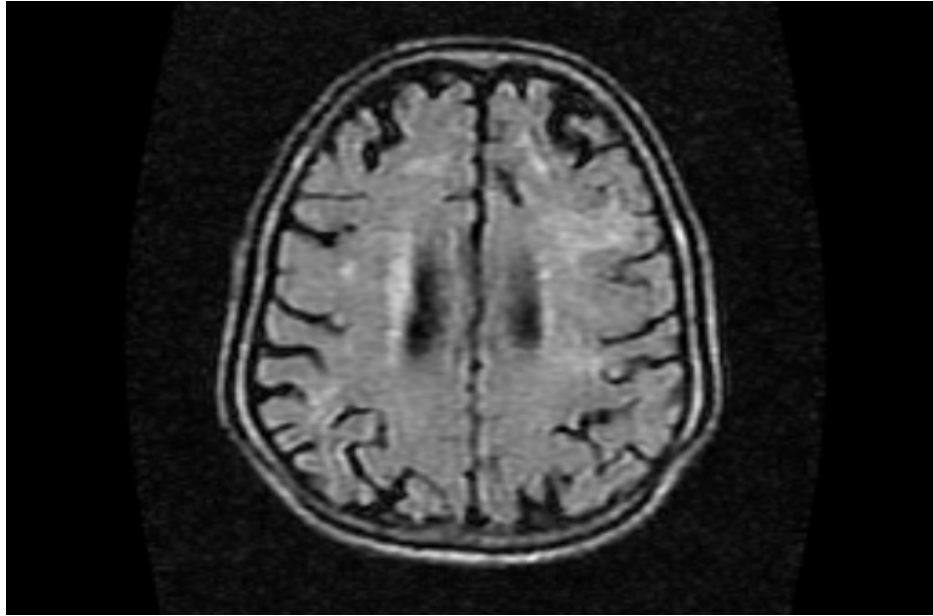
Multiple lacunar infarct and periventricular white matter changes on flair sector of MRI
